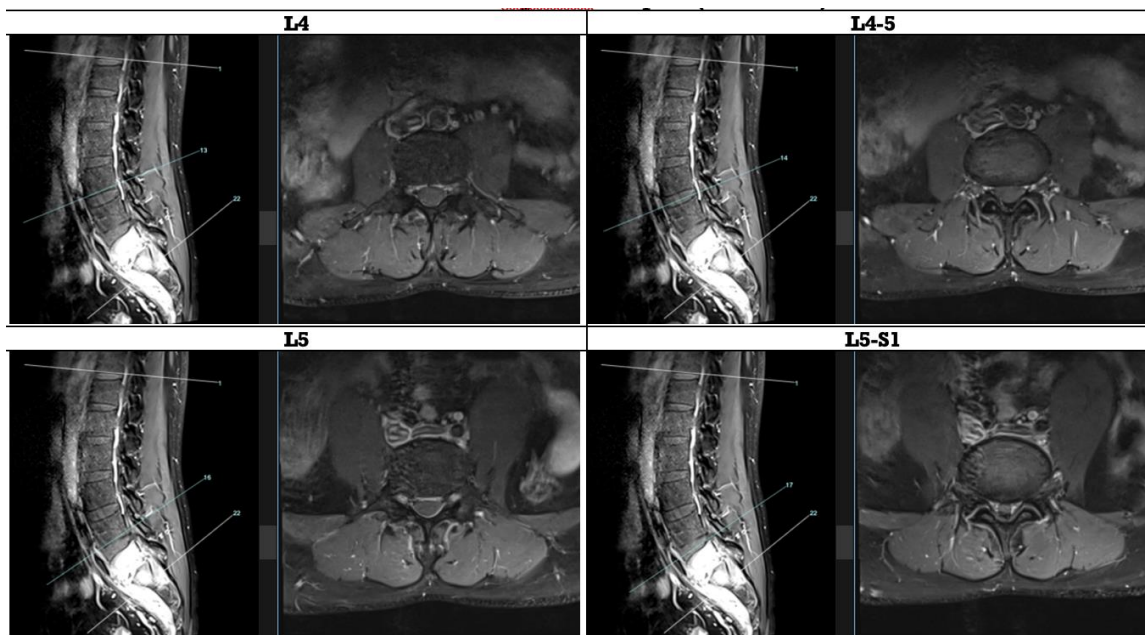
Lumbar Spine MRI T1W Axial View with Contrast
